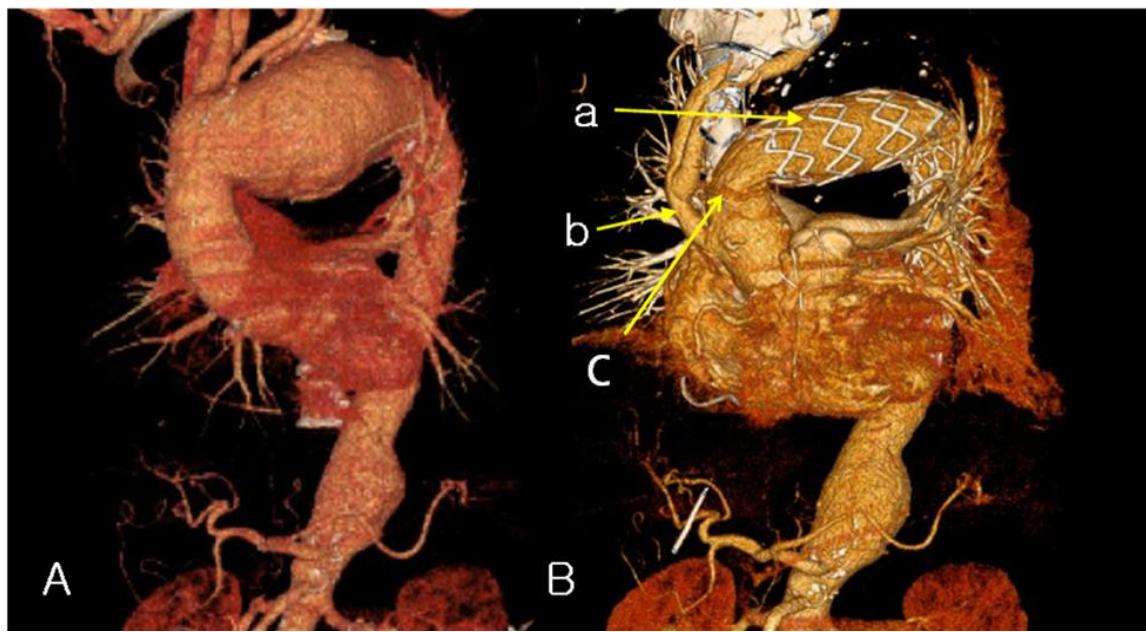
Pre- (A) and post-procedural CT findings of a 67-year male patient, diagnosed as aortic arch aneurysm who underwent hybrid aortic surgery. An endovascular stent-graft is placed from the beginning of arch to descending thoracic aorta (B-a). Arch vessels are debranched from the arch, and then innominate and left common carotid arteries are bypassed to the proximal ascending aorta using a Y-graft (B-b). Open fixation site of stent proximal landing (B-c).
